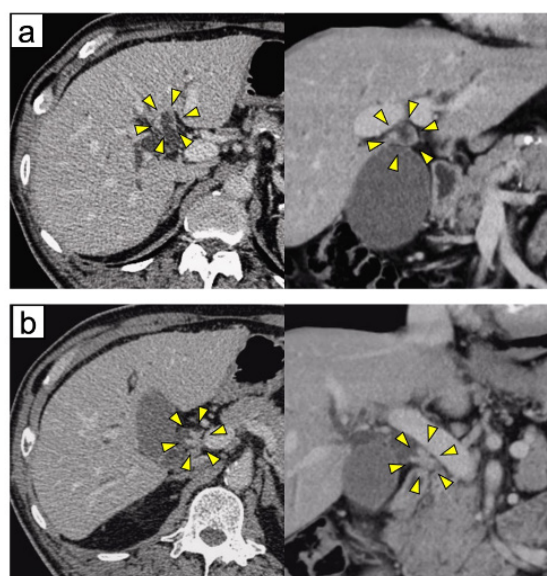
Preoperative contrast-enhanced computed tomography. Axial (left) and coronal (right) images reveal bile duct wall thickening, predominantly involving the root of the left hepatic duct (a) and extending to confluence of the cystic duct (b). The lesion is indicated by yellow arrowheads. There was no tumor invasion of the right hepatic artery.
